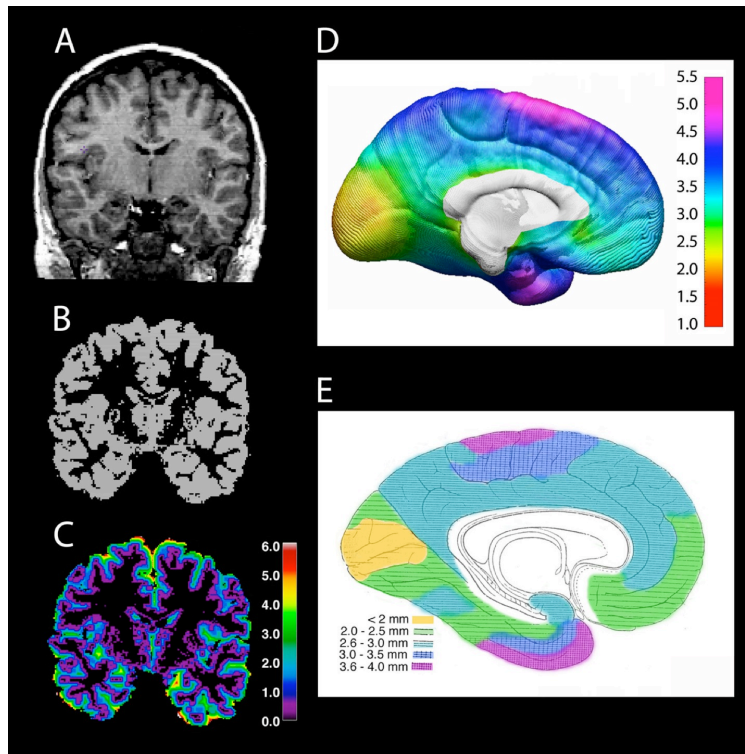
Cortical thickness analysis. Panels A-C show a single representative slice for one subject: (A) Raw T1-weighted anatomical MRI scan. (B) Gray/white matter tissue segmentation. (C) Gray matter thickness image, with thickness (mm) coded by color (warmer colors overlie the areas with the thickest cortex). (D) shows an in vivo average cortical thickness map generated by performing this analysis on a cross-sectional sample of 45 subjects. The brain surface rendering is color-coded according to the underlying cortical thickness (mm) and the color bar at right. The regional variations in cortical thickness can be compared to an adapted version of the classical Von Economo postmortem cortical thickness map (E), which has been color-coded in a similar manner over the original stippling pattern to highlight the similarity between the two maps (Sowell *et al.*, 2004a; Von Economo, 1929).
